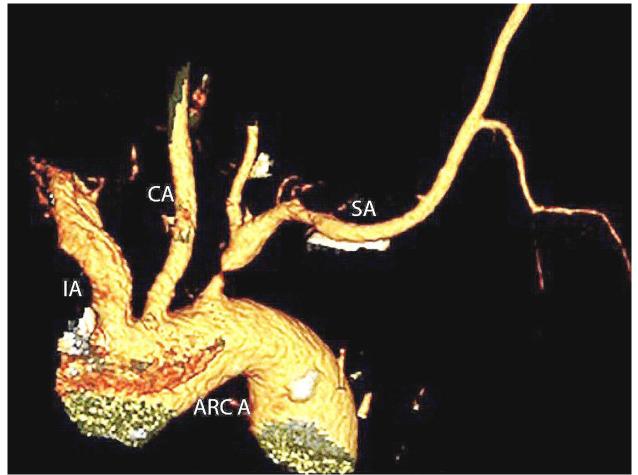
Preoperative imaging of the left 'subclavian steal syndrome' and severe stenosis left subclavian artery on computed tomography angiography.
